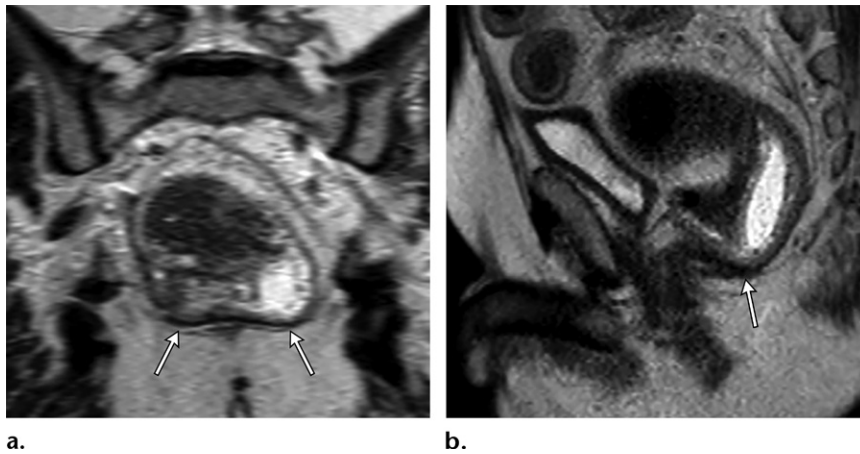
Ileoanal pouch anastomosis in an 81-year-old man with a history of ulcerative colitis after total colectomy and ileoanal pouch anastomosis who presented with an inability to defecate despite the urge to do so and intense pressure, presumably due to gas buildup and rectal spasms. Coronal (a) and sagittal (b) left paramedian T2-weighted MR images acquired while the patient was straining show marked bowing of the ileococcygeus muscles bilaterally (arrows in a) that is even more pronounced in b (arrow). There is decreased angulation between the ileal pouch and the anus (b) on straining, thereby hindering evacuation. The ileoanal junction (off plane) never passes below the PCL, but the distal ileum balloons below the PCL bilaterally (not shown).
